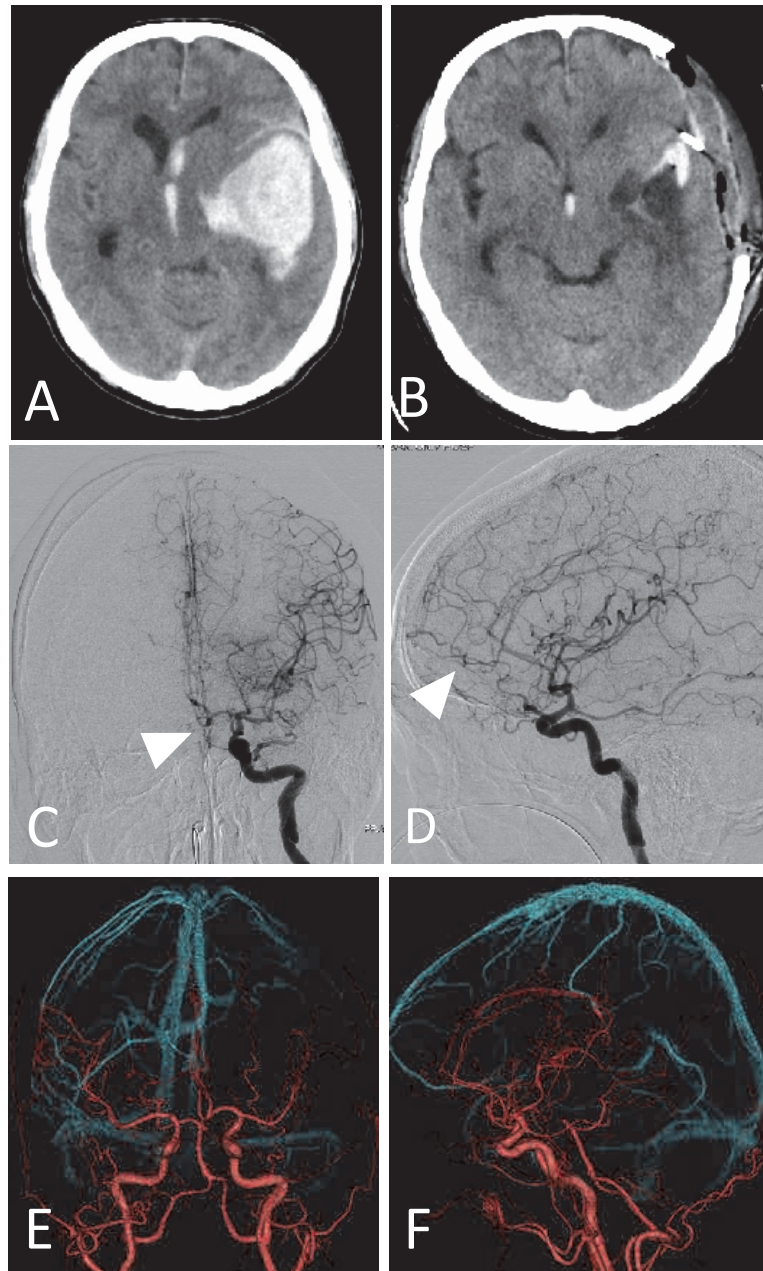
(A) Computed tomography image after attempts intravascular surgery showing the enlargement of the hematoma. (B) Computed tomography image after microsurgery showing that the temporal hematoma is evacuated and clipped. (C, D) Cerebral angiography 17 days after the first microsurgery shows a venous reflux to SMCV is remaining and a new drainage root to the superior sagittal sinus (white arrow). (E, F) Computed tomography image two years after the second microsurgery showing that the DAVF disappeared and there is no recurrence.
